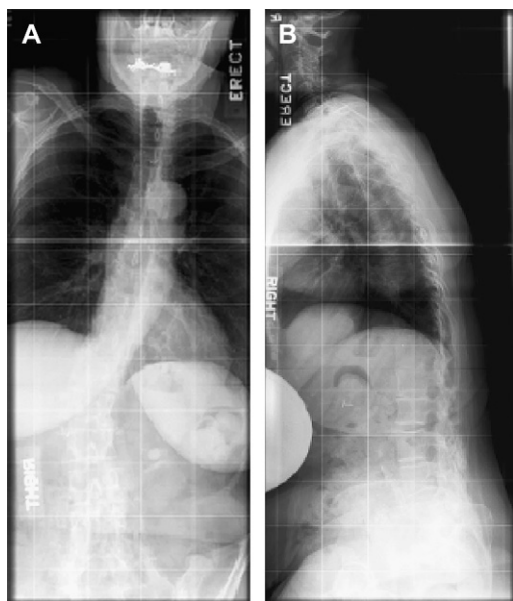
(A) Anterior-posterior radiograph of a 72-year-old woman with previous lumbar fusions 14 years before presentation. The patient presented with back pain and an inability to stand up straight. (B) Sagittal standing films show the patient's loss of lumbar lordosis and positive sagittal balance.
